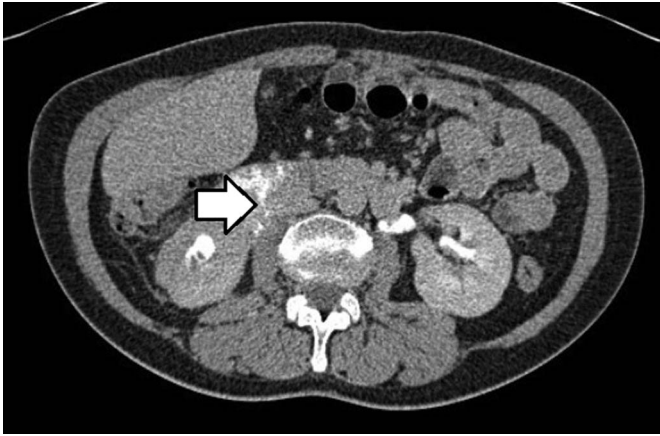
The white arrow denotes contrast extravasation into the gastrointestinal system confirming right pyeloduodenal fistula on single-photo emission computed tomography imaging.
